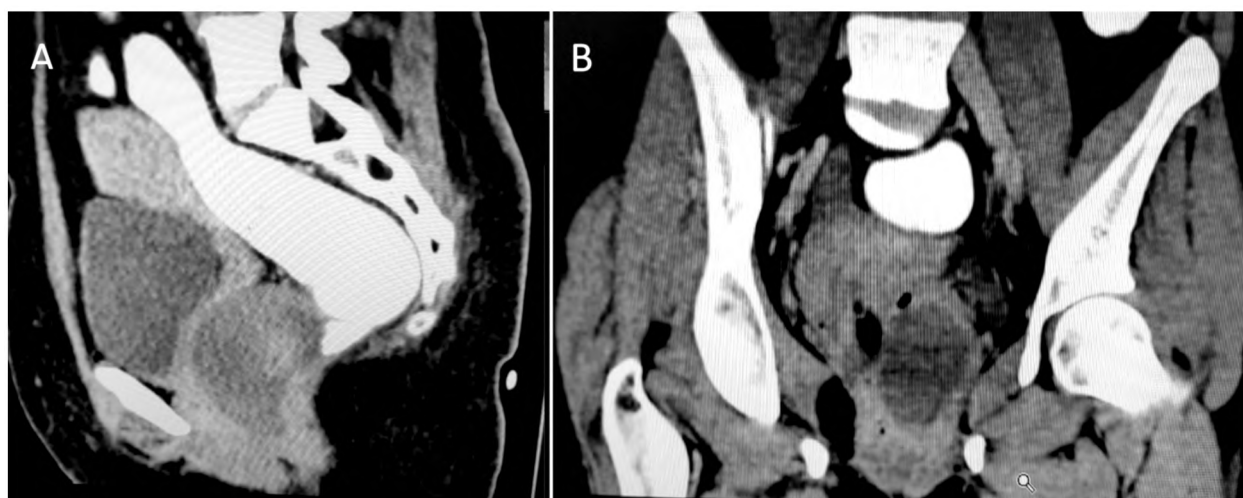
CT saggital (A) and coronal (B) Planes showing a cystic lesion located between the vagina antriorly and the rectum posteriorly.
